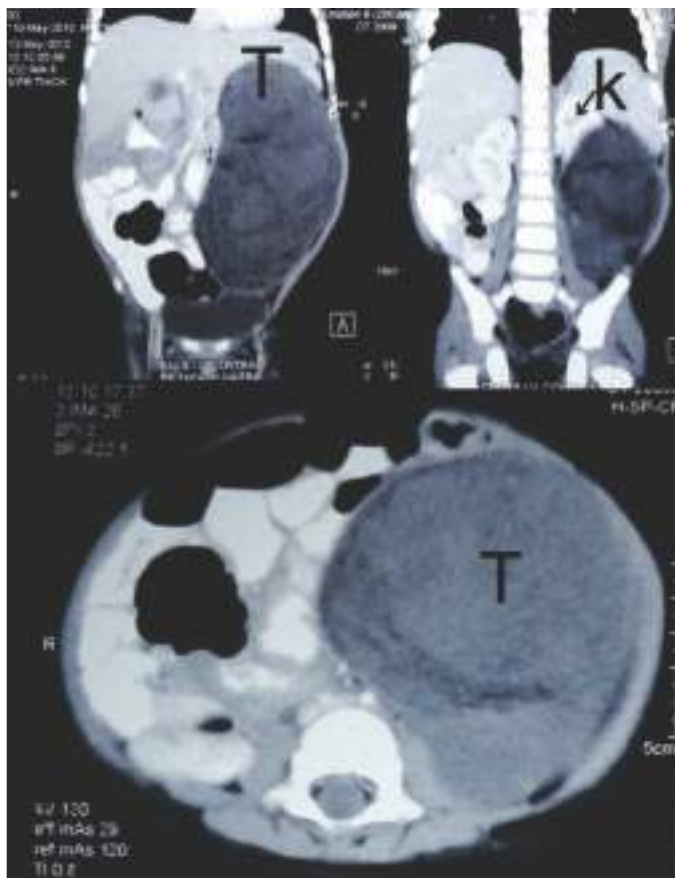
CT scan showing the mass; left kidney is pushed upwards and medially
